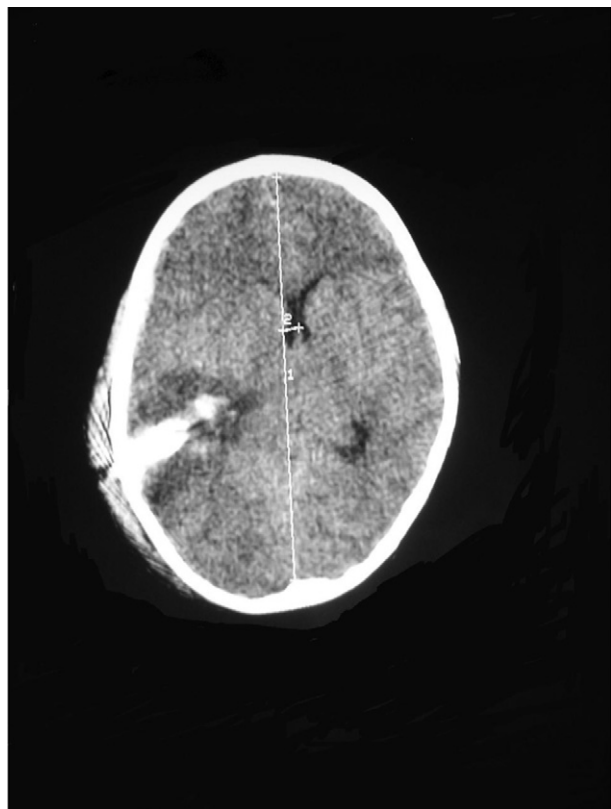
CT head showing foreign body in the right parietal area.
